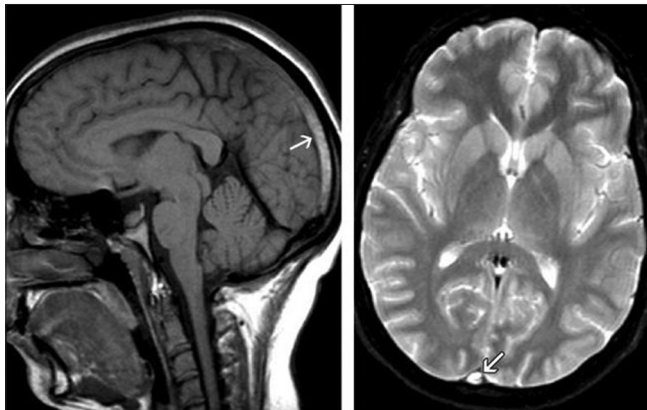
Thrombosis of the superior sagittal sinus and venous infarction in a 25-year-old woman who was 34 weeks pregnant and developed headaches and blurring of vision. Sagittal T1-weighted, axial T2-weighted magnetic resonance images show high signal intensity in the superior sagittal sinus (arrow)
